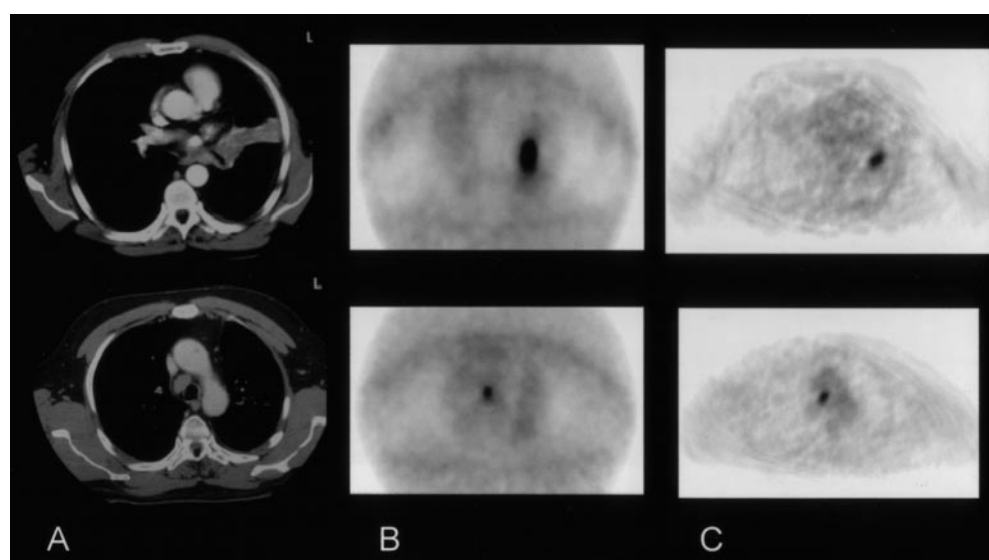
CT (A), CGC (B), and PETac (C) studies of a patient with small cell carcinoma and mediastinal lymph node involvement (patient 1; *first row*, primary tumour, *second row*, lymph node metastases). CT, CGC and PETac demonstrate increased FDG uptake in the enlarged mediastinal lymph node. Atelectatic lung tissue visualized on the CT image shows no increased FDG uptake
